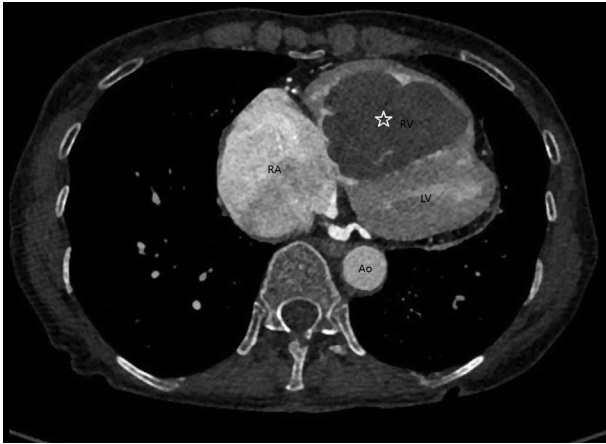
Computed tomographic imaging showing a filling defect (star) in the right ventricle (RV). Ao, aorta; LV, left ventricle; RA, right atrium.
